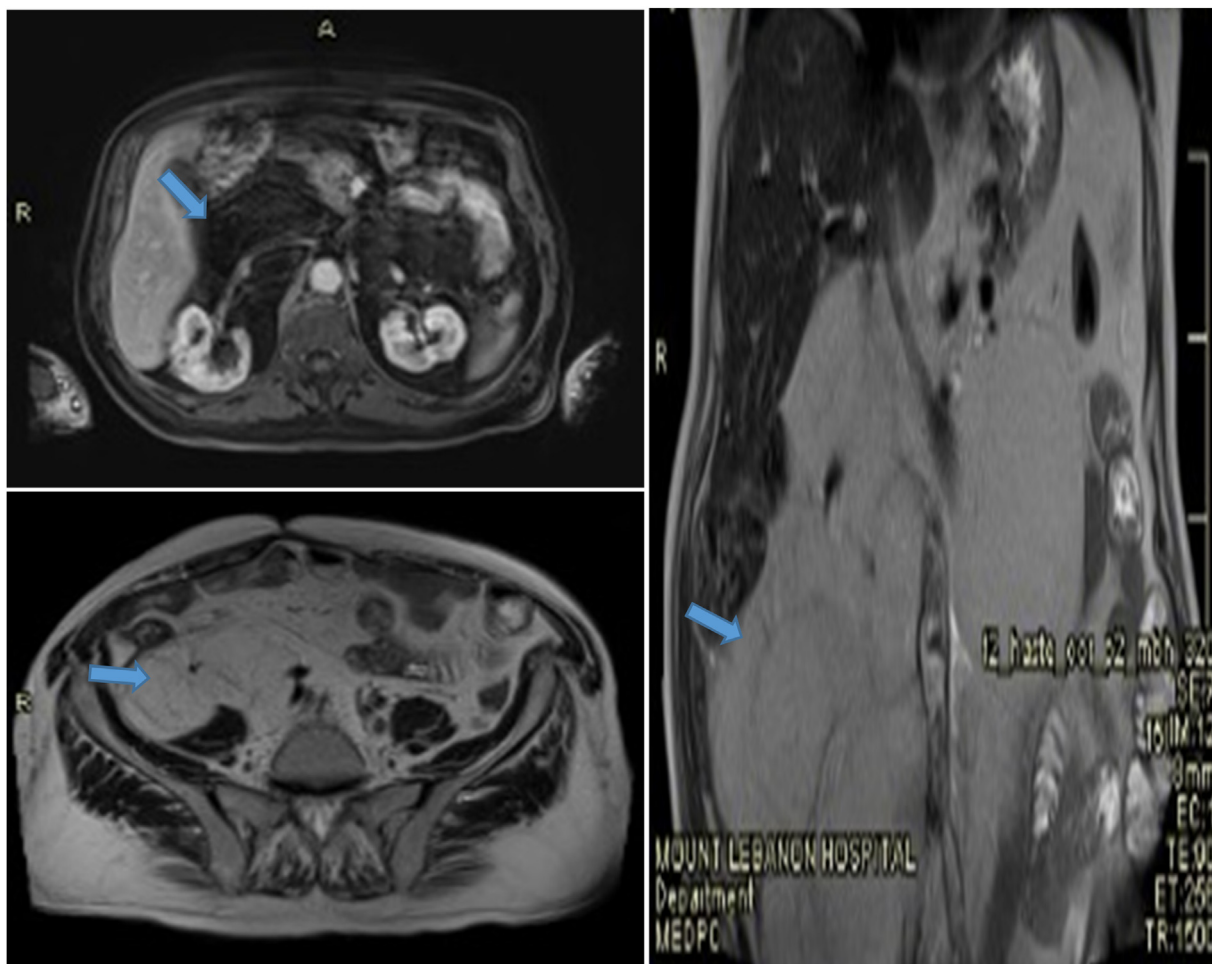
CT scanner and MRI: Recurrence of the right retroperitoneal liposarcoma (Blue Arrow) encapsulating the right renal vessels.
